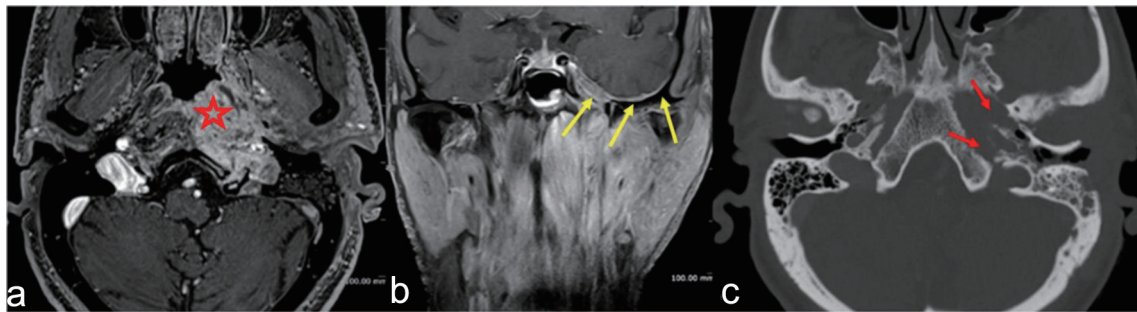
Magnetic resonance images in contrast-enhanced sequences, axial (a) and coronal (b). Axial cut in computed tomography (CT) (c). Infiltrative soft tissue mass in the deep spaces of the suprahyoid neck deforms the nasopharynx (red star); ipsilateral infiltration and erosion are noted on the clivus and petrous apex (red arrows). Pathological tissue extends to the oval foramen; dural thickening and enhancement on the middle cranial fossa floor and Meckel's fossa are appreciated (yellow arrows).
